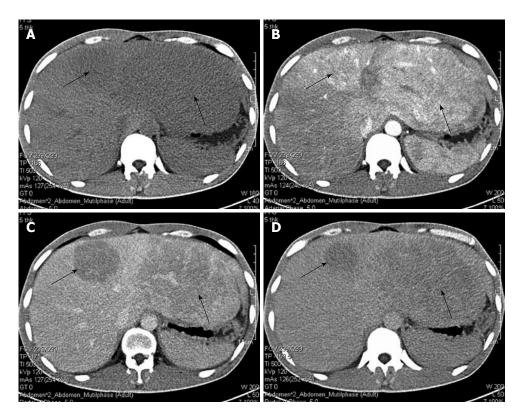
Computed tomography manifestation of the male patient. A: Low-density masses in the plain phase (black arrows); B: In the arterial phase, a strong contrast-enhancing effect with low-density in center was observed; C: In the portal phase, tumors had almost washed out the contrast agent, but a weak contrast-enhancing effect was sustained; D: Low-density masses in the delayed phase.
